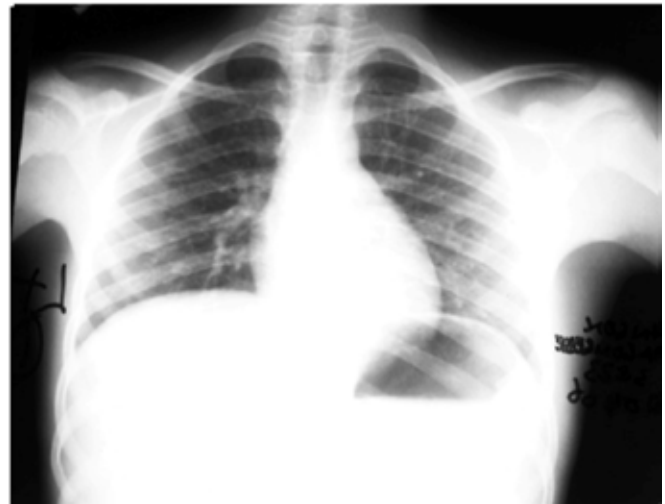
A postero-anterior chest X-ray showing no left pleural effusion
